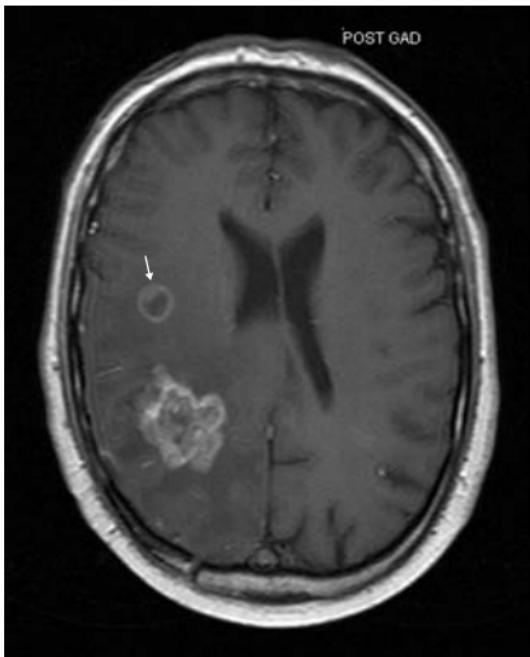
Glioblastoma multiforme. (a) Axial T2W and (b) post contrast enhanced axial MRI. Irregular enhancing heterogenous right parietal mass with surrounding abnormal white matter within which is a second area of enhancing tumour more anteriorly (white arrow).
